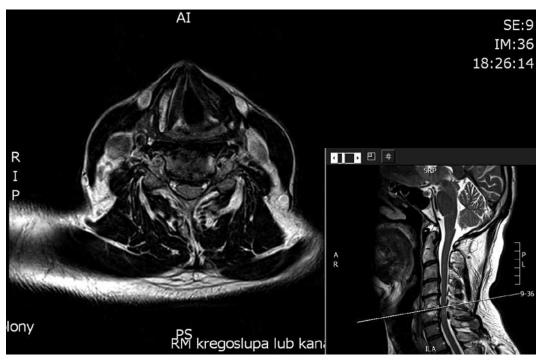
T2 MRI image of spinal cord compression due to cervical spondylosis
